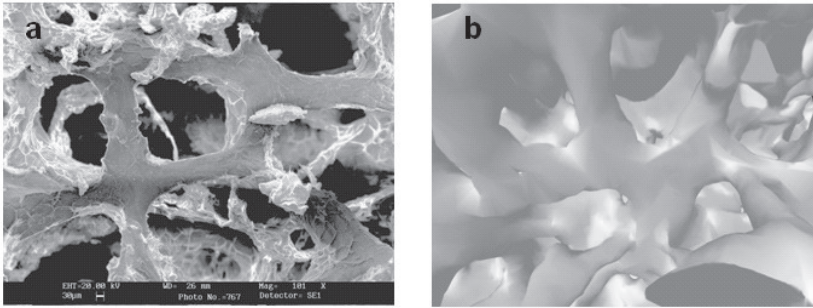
Trabecular bone network of a 50-year-old man: (a) SEM image (courtesy of Prof. D. Ronca, Orthopedic Clinic, II University of Naples, Italy); (b) 3-D reconstruction of micro X-ray CT (courtesy of Prof. S. Rengo, School of Dentistry, University of Naples Federico II, Naples, Italy).
